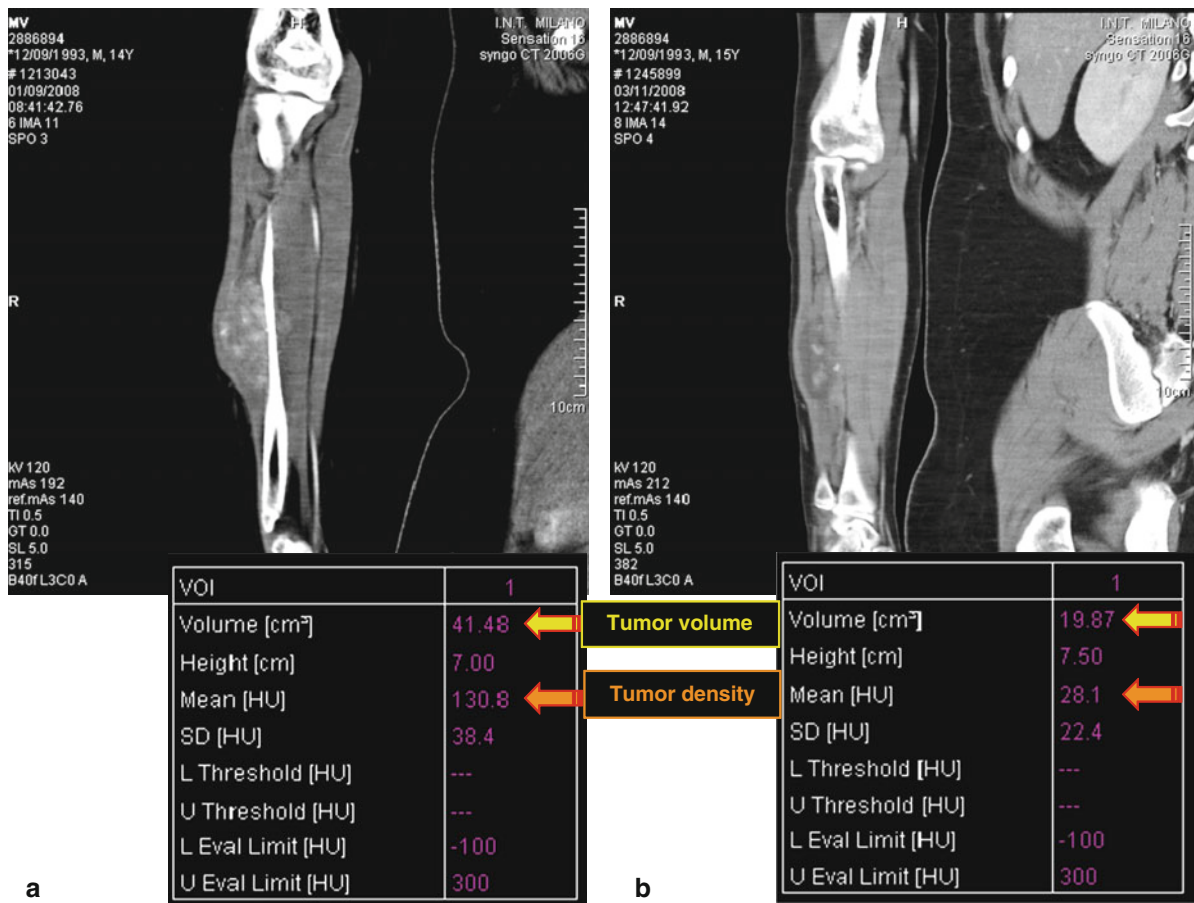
Computed tomography scan of synovial sarcoma of the right forearm: (a) at onset, before chemotherapy; (b) after three courses of chemotherapy with ifosfamide and doxorubicin. Response to chemotherapy is shown by volume reduction as
